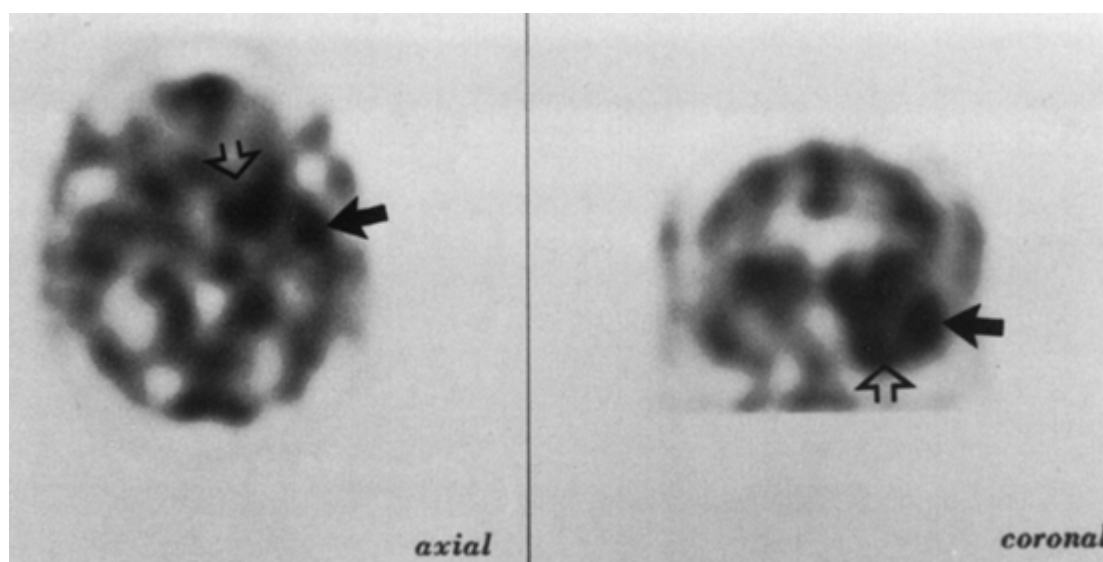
Patient No. 1. Ictal SPECT. Axial and coronal views showing increased activity in left medial (*open arrows*) and lateral (*closed arrows*) temporal lobe.
